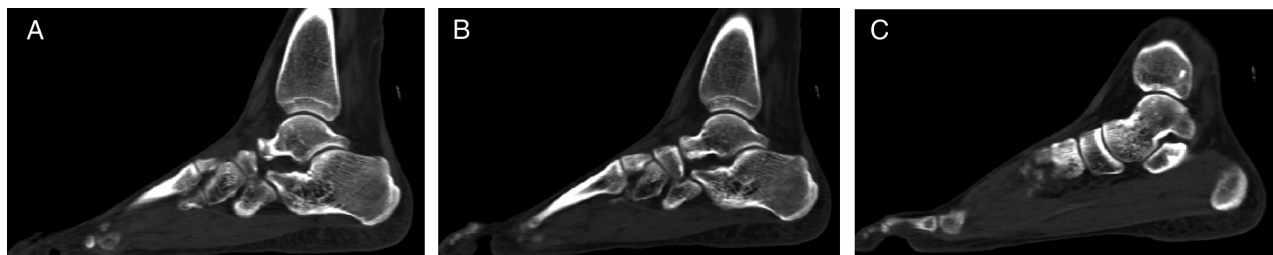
(A to C) Computed tomography scans revealed no evidence of bone coalitions in the foot or ankle.
